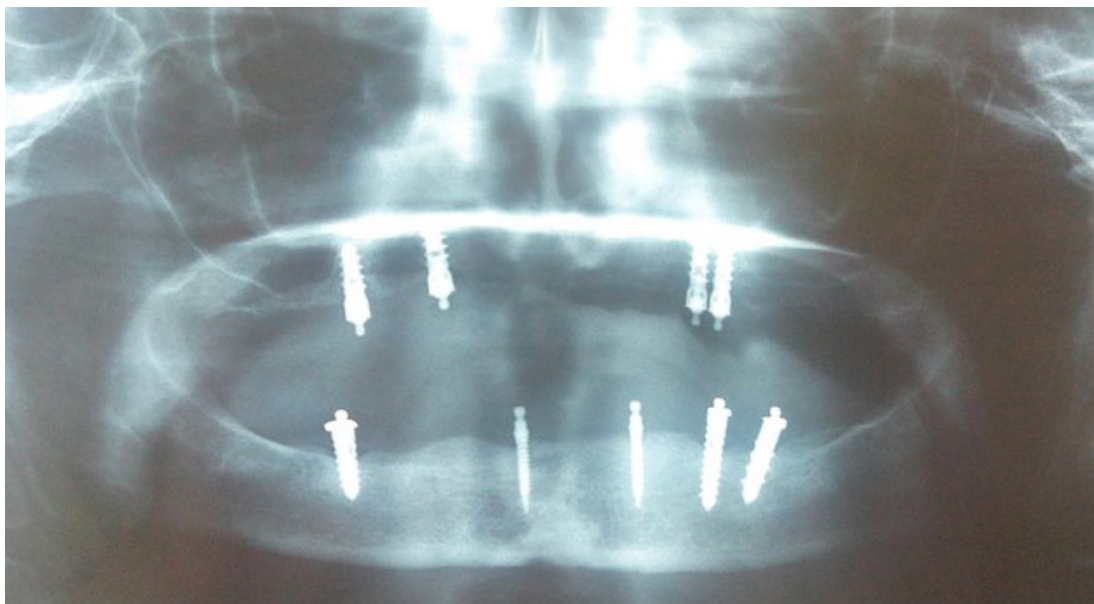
Panoramic X-ray after inserting new implants: in the mandible were used 2 one-piece implants.
